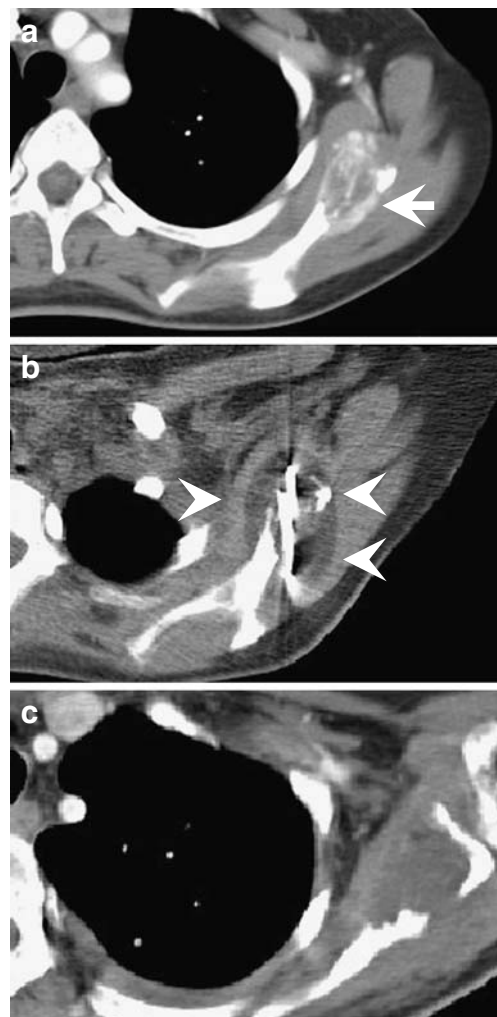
CT axial images at the level of the scapula. a Enhancing osteolytic paraganglioma metastasis involving the scapula (*arrow*). b Two percutaneously placed cryoprobes in the soft tissue lesion with an ice ball encompassing the tumor (*arrowheads*). c Contrast-enhanced CT 3 months following ablation showing no enhancement in the treated area. Prior to cryoablation, the worst pain was 5/10. Four weeks, 8 weeks and 24 weeks after cryoablation, the worst pain was 2/10, 1/10, and 0/10, respectively
